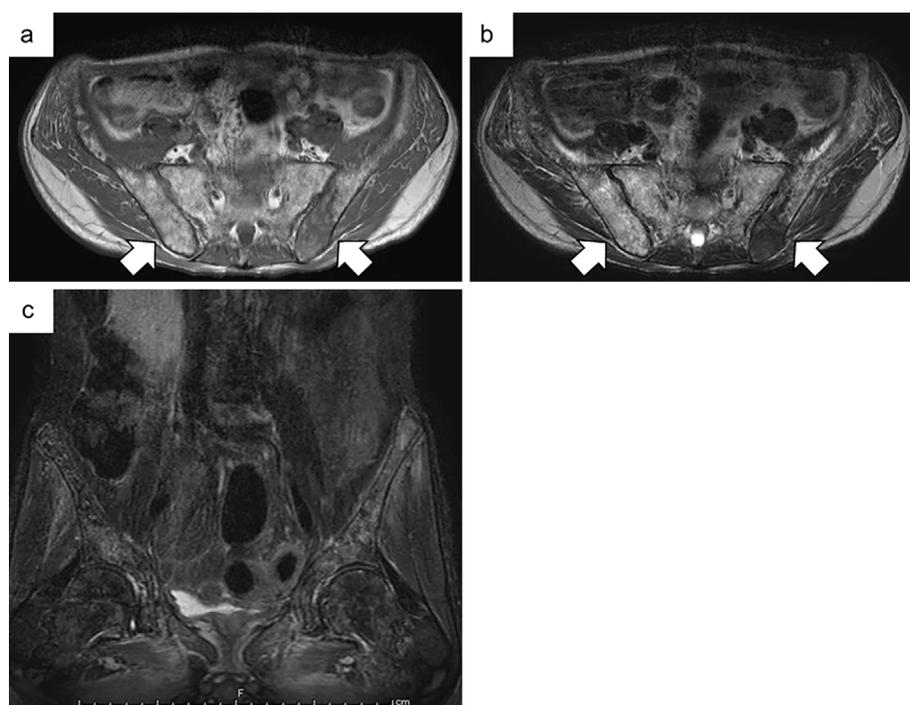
Magnetic resonance images showing different abnormal signals in the bilateral iliac bone marrow (arrow). (a) Axial T1-weighted magnetic resonance image. (b) Axial T2-weighted magnetic resonance image. (c) Coronal high short T1 inversion recovery image.
